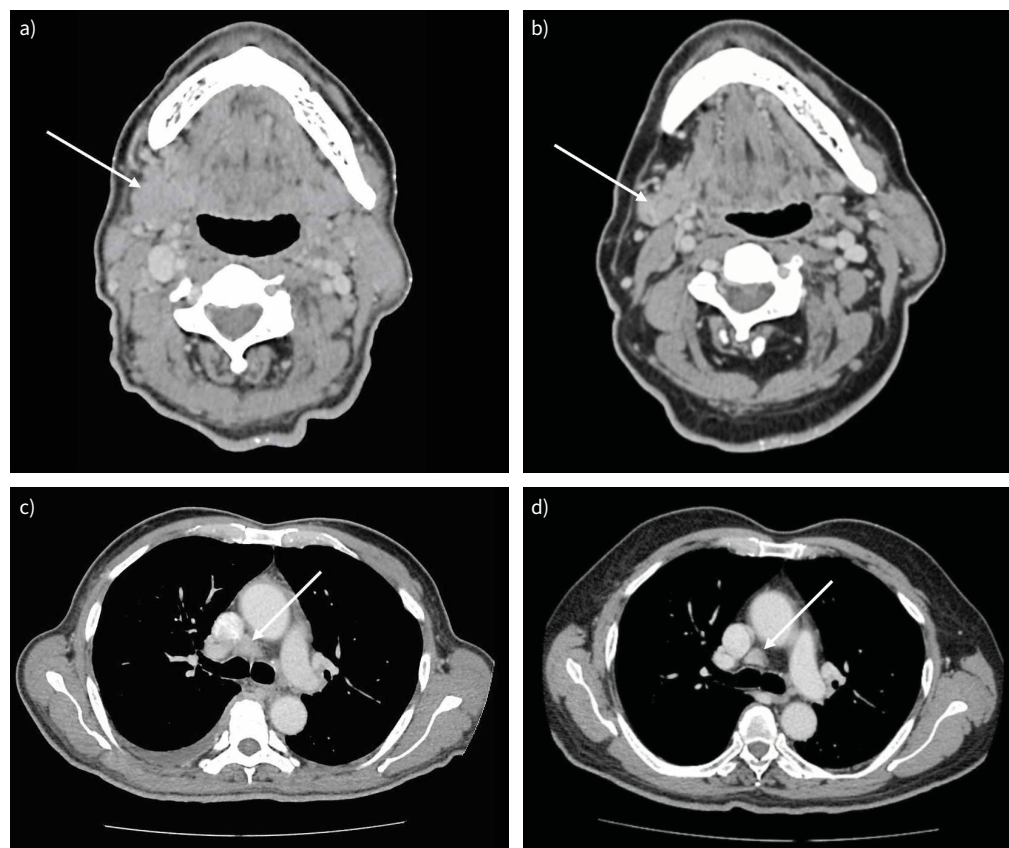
3-month surveillance computed tomography (CT) scan at the level of submandibular glands as well as station 4R lymph node. a, c) CT scan on presentation, b, d) 3-month surveillance CT scan.
